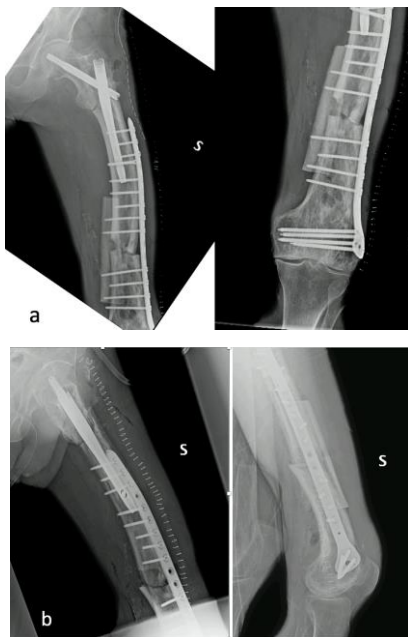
Immediate post-operative, anteroposterior (a) and lateral radiographs (b). Subtrochanteric fracture stabilized by intramedullary nailing and middle third diaphyseal fracture treated by plate and bone allograft with correction of pre-existing deformity.
